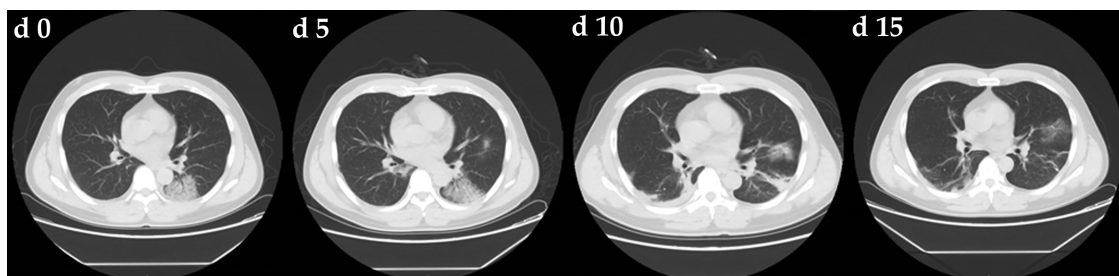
Chest computed tomographic images of a 42-year-old patient with refractory coronavirus disease 2019 pneumonia, obtained on 19 January (day 0), 24 January (day 5), 29 January (day 10), and 3 February (day 15) 2020. The patient reached remission on day 15.
